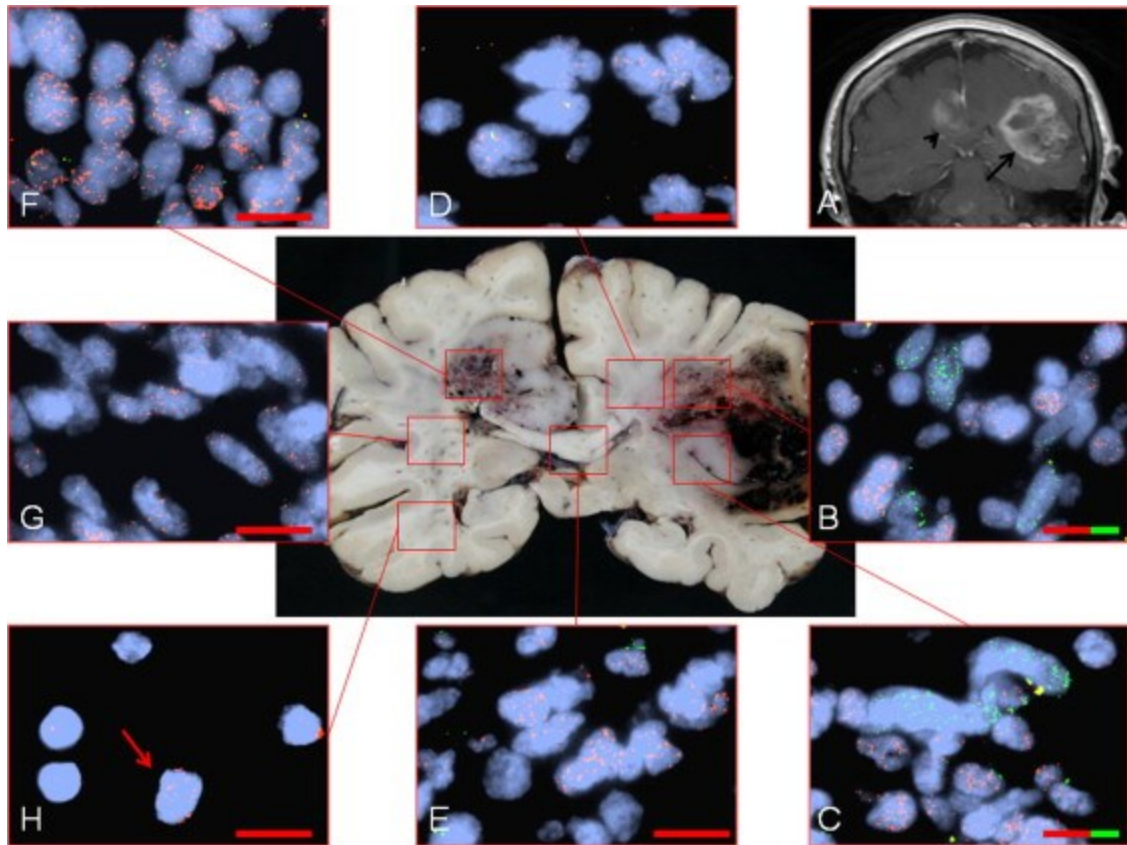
Autopsy of mosaic GBM case. (A) The MRI with contrast displays a large primary tumor with ring enhancement in the left parietal lobe (arrow) and a smaller secondary lesion in the right cingulate gyrus (arrowhead). (B and C) The main parietal tumor mass shows a mixture of cells with either EGFR (red) or PDGFRA (green) amplification, while the invasive edge of the main tumor (D) and corpus callosum (E) are infiltrated by GBM cells composed exclusively of cells with EGFR amplification. The second mass in the right cingulate gyrus is also composed of EGFR-amplified cells (F), and infiltrates (G) into the white matter of the right temporal lobe (H, arrow). The colors indicate the percentage of EGFR-amplified or PDGFRA-amplified subclones in each section, and the scale bars represent 40 μm . Adapted from Ref. [40].
